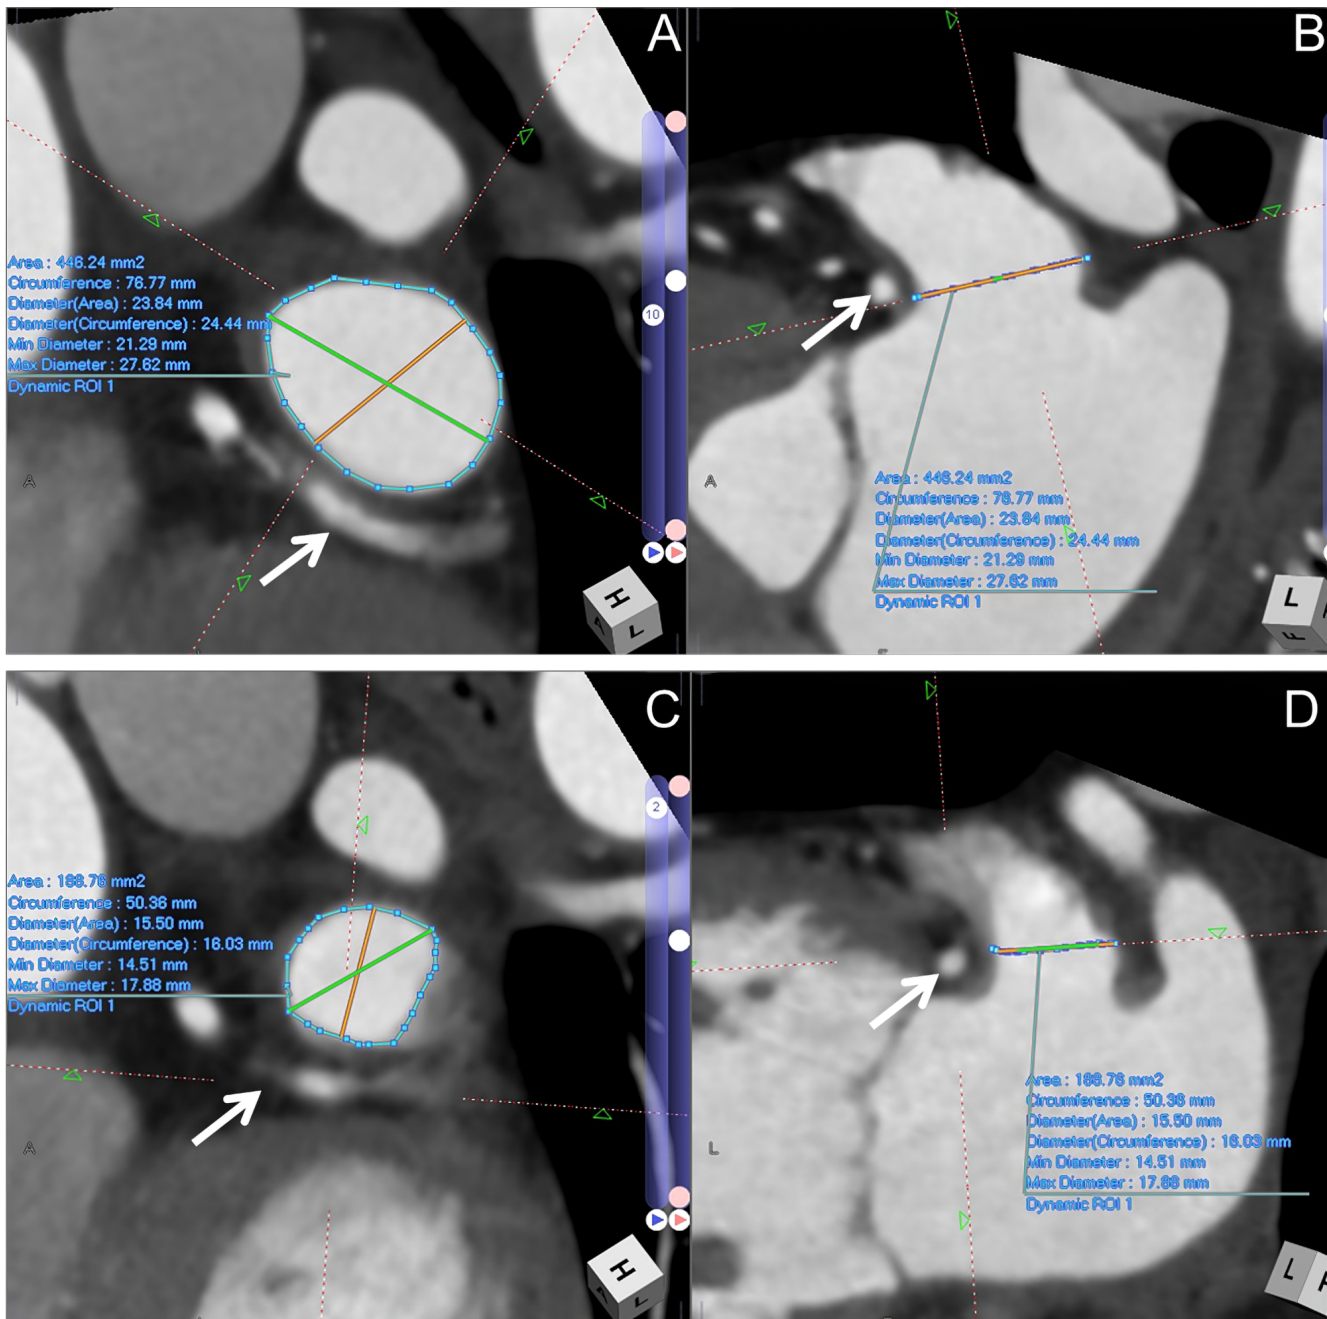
Computed tomography of a 70-year-old patient in sinus rhythm. *Panels A and B* show multiplanar reconstructions of the left atrial appendage (LAA) at 45% of the peak R-wave to R-wave. *Panel A.* Tracing of the LAA ostium showing an area of 446 mm². *Panel B.* plane of the LAA ostium. The arrows mark the left circumflex coronary artery. *Panels C and D* show multiplanar reconstructions of the same patient at 5% of the peak R-wave to R-wave with significantly smaller LAA dimensions. *Panel C.* Tracing of the LAA ostium showing an area of 188 mm². *Panel D.* plane of the LAA ostium.
